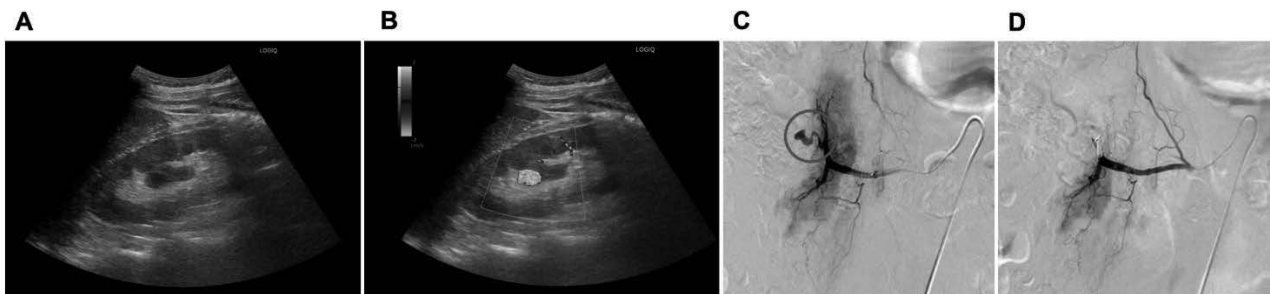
Renal artery pseudoaneurysm identified by screening with ultrasound examination (patient 2). (A) On postoperative day 7, a 15 mm anechoic area was observed within the kidney using the B-mode method in ultrasonography. (B) The same area exhibited a mosaic blood flow pattern on color Doppler imaging. (C) On postoperative day 10, an angiographic examination revealed an abnormal blood flow with saccular dilation, leading to a diagnosis of renal artery pseudoaneurysm. (D) Coil embolization was performed, and the disappearance of the abnormal blood flow was confirmed.
